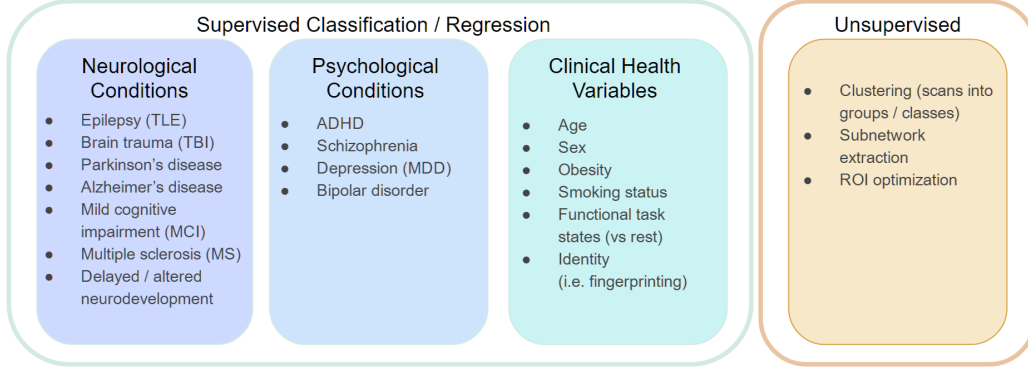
Machine learning tasks that have been performed using MRI based connectome data.
